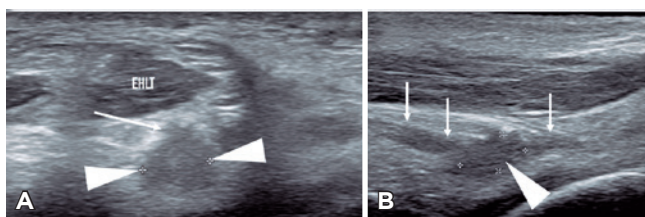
Ultrasonography showing a neuroma-in-continuity. A) Axial plane. B) Longitudinal plane. Short white arrows show the path of the deep peroneal nerve in longitudinal plane, proximal and distal to a neuroma in lateral continuity (arrowheads) adjacent to the nerve visualized in axial plane (long white arrow).
